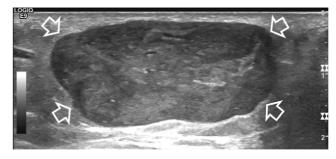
Longitudinal sonographic image demonstrates a solid, well-defined, homogenously hypoechoic mass (outlined by open arrows) within the subcutaneous tissues. The top of the image is superficial, and the left of the image is proximal. The scale on the right side of the image is in centimeters.
